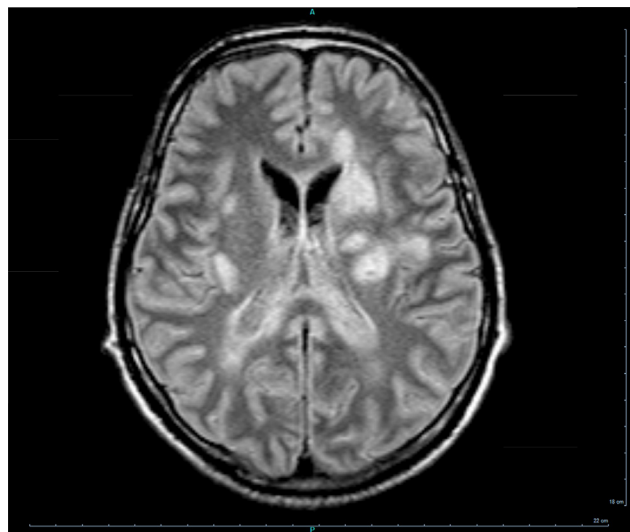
Cerebral MRI showing multiple diffuse and bilateral brain abscesses (seven on this section).
